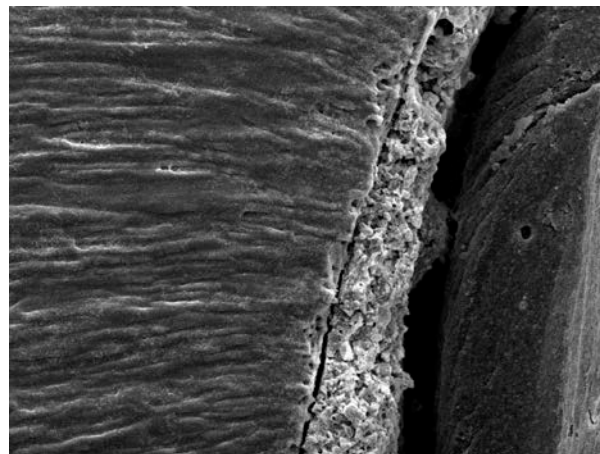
Group 4: Resin tags (G-Premio Bond) after Ultrasonic Activation and adhesive failure (SEM x270).
